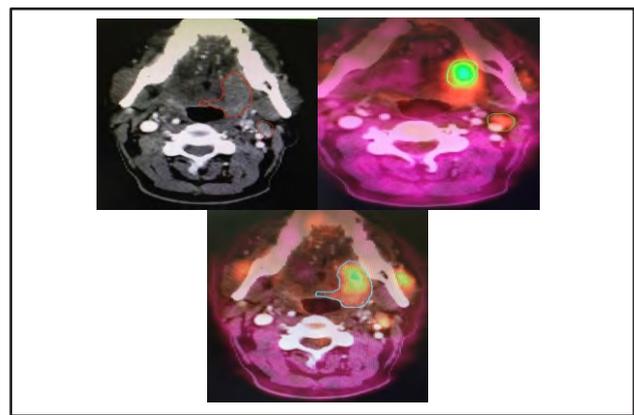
GTV delineation in a case of ca tonsil (a) Gross tumor volume on CT scan (b) Gross tumor volume on PET scan (c) Gross tumor volume on fusion of PET-CT scan
